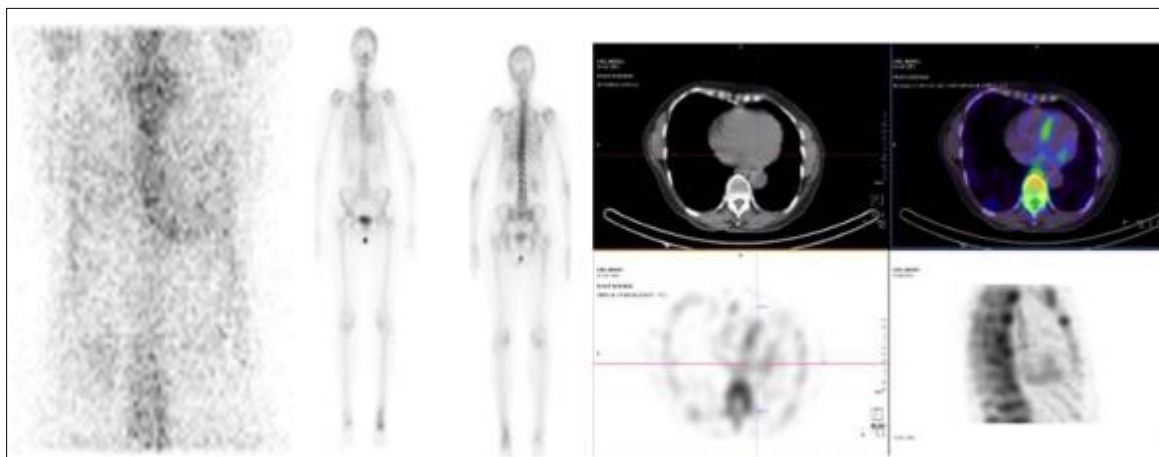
Whole-body DPD scintigraphy in late-phase images showing cardiac hyperfixation without extinction of the bone frame (stage 2 of Perugini). Cardiac tomographic slices combined with whole-body DPD scintigraphy confirm myocardial hyperfixation (and not intracardiac blood pool as sometimes observed in cases of slowed blood flow)
